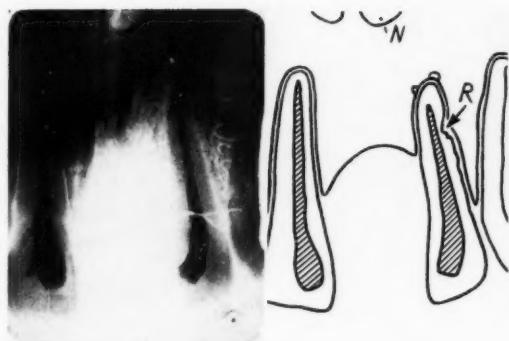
Roentgenogram and tracing made immediately after the root canal filling
